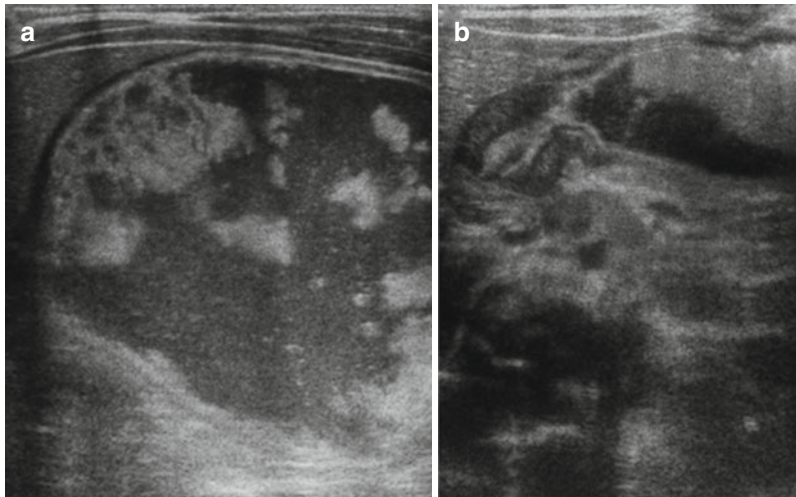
(a, b) Ultrasound shows indirect signs of HPS: the stomach is distended and gastric peristalsis is increased, causing the “foamy” aspect of the gastric
